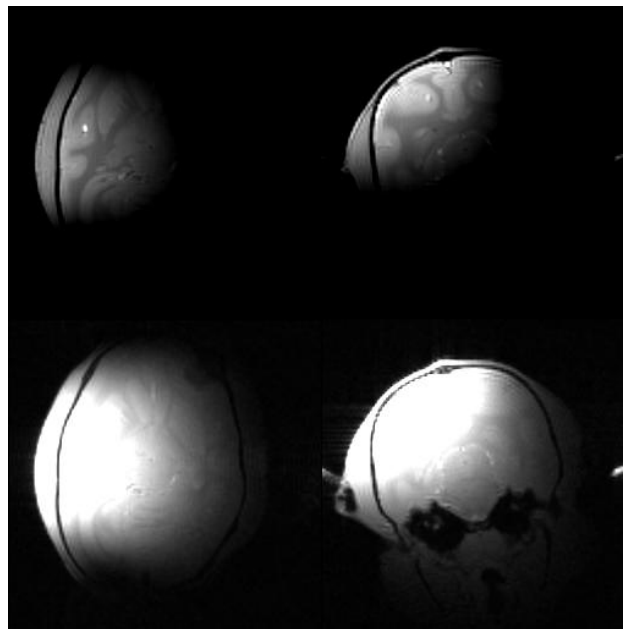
Partial 3D head MRI scans. Because the signal drops rapidly from the coil, the contrast needs to be adjusted to permit visualization. Bottom row: two views with contrast adjusted in order to show details in regions of low intensity. Top row: Same images with contrast adjusted to show details in regions of high intensity. When the contrast is adjusted for high intensity regions, the rest of the head is not visible. When it is adjusted for low intensity regions, the area close to the coil is saturated.
